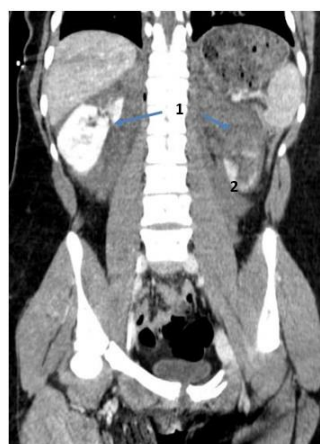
Coronal reconstruction of abdominopelvic CT in the venous phase, asymmetry in the renal contrast enhancement is observed, being practically absent in the left (1) except for an irregular uptake in the lower pole (2) which may suggest the presence of some polar branch.
